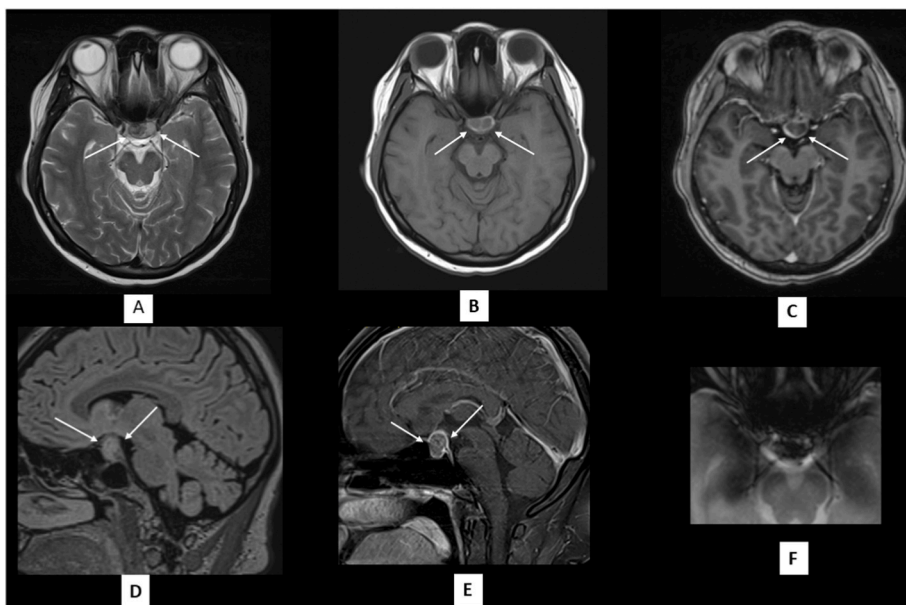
Contrast-enhanced MRI brain. Axial T2 sequence (A) showing an isointense lesion with central heterogeneous low signal intensity areas within (white arrows). On Axial T1 pre-contrast (B) and T1-post contrast (C), sagittal T1 pre-contrast (D) and post-contrast (E), the lesion showed rim-enhancement (white arrows). Areas of T2 low signal are iso-intense on T1 pre-contrast. Magnified image of the lesion in axial GRE (F) showing blooming artefact within the lesion. This constellation of findings are suggestive of bleeding within a pre-existing pituitary adenoma.
